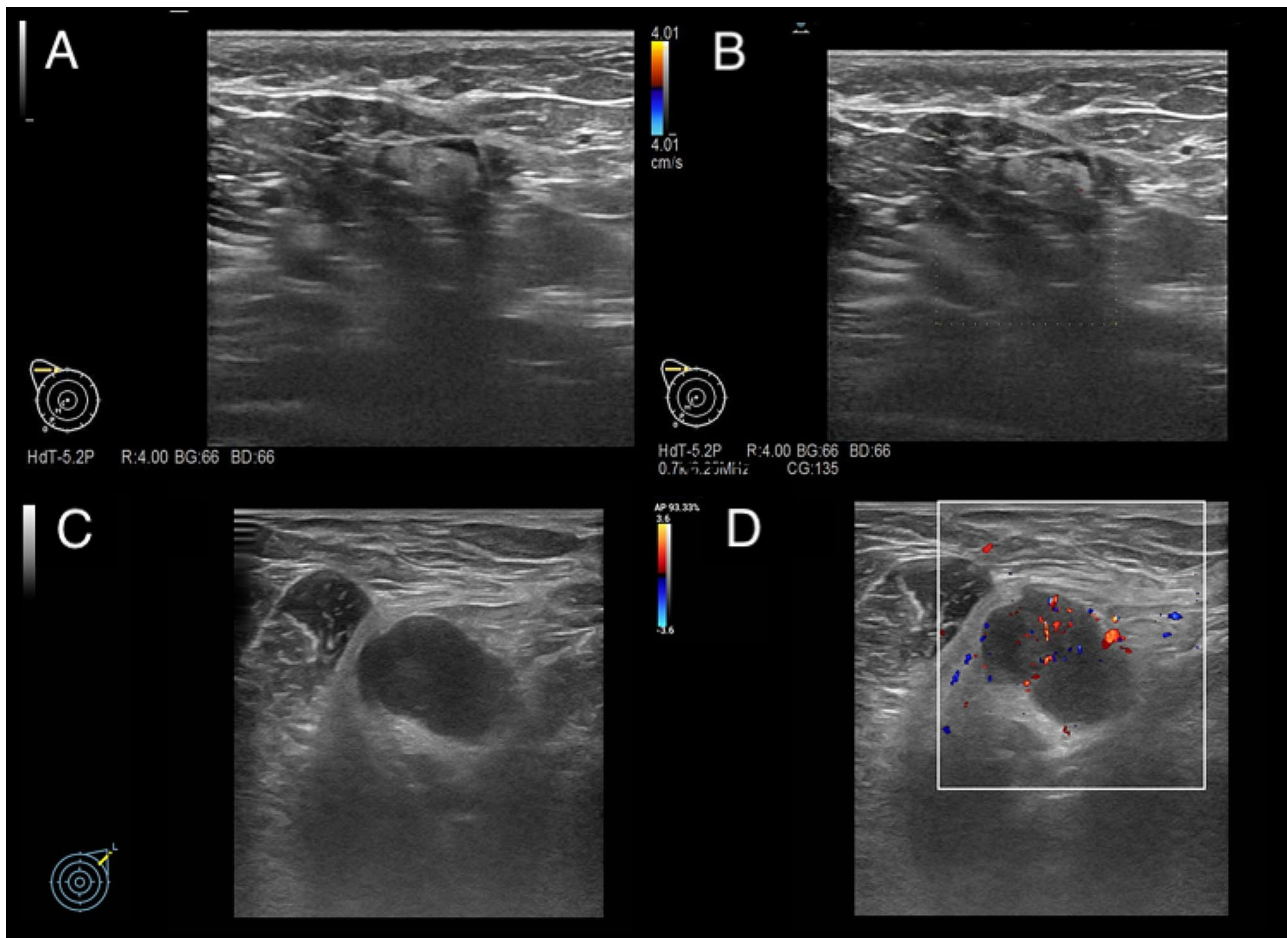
An example of ultrasonographic lymph node imagines analysis. (A) showed an ultrasound image of the right axilla exhibiting no signs of lymph node metastasis. (B) showed a color Doppler flow imaging (CDFI) image of the right axilla, indicating the absence of lymph node metastasis. (C) showed an ultrasound image of the left axilla showcasing lymph node metastasis, featuring a 24.0*16.0 mm mass identified as a lymph node. (D) showed a CDFI ultrasound image of lymph node metastasis in the left axilla, revealing discernible colored blood flow within the affected lymph node
